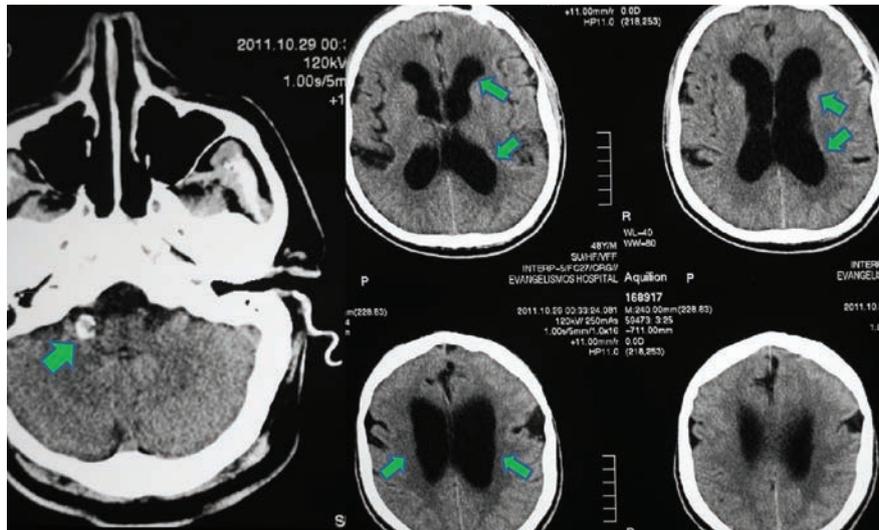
Axial computed tomography brain scan showing on the left an ectatic and calcified basilar artery and extensive dilatation of ventricles on the right.
